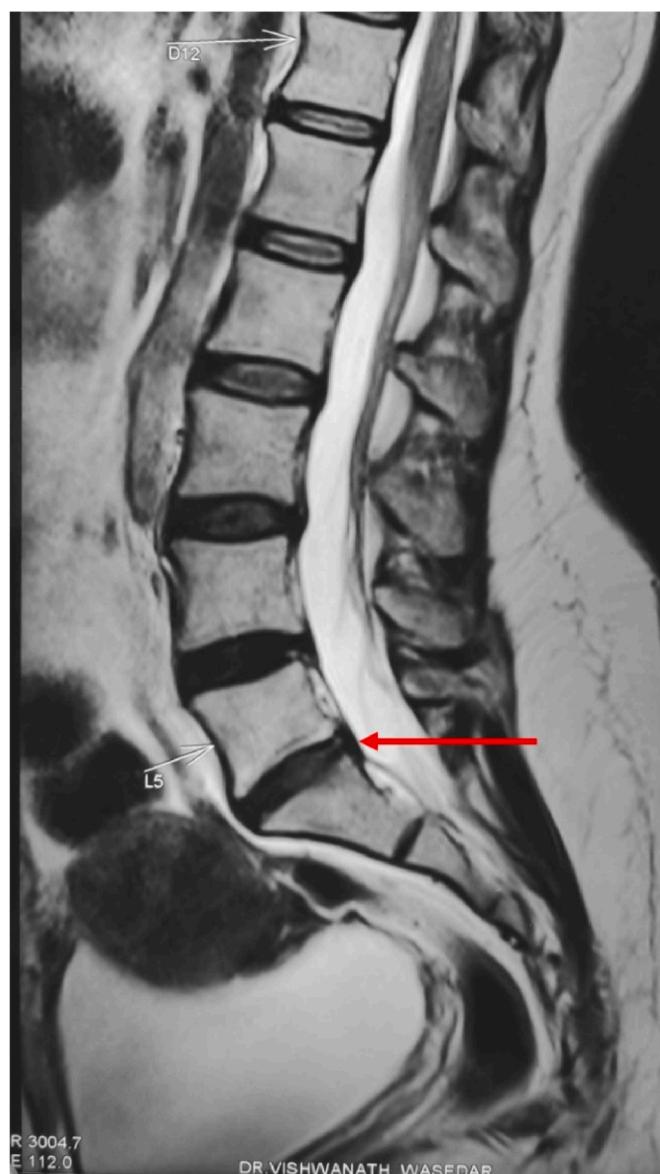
The red arrow in sagittal view of the T2-weighted image shows complete interval resolution of L5-S1 disc sequestration.
